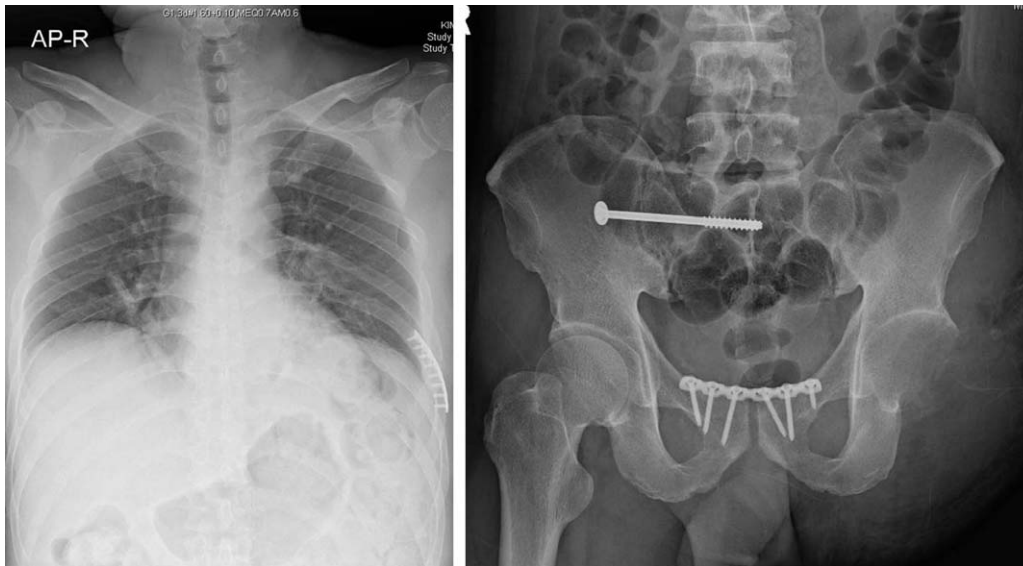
Postoperative x-rays of chest and pelvis AP.
